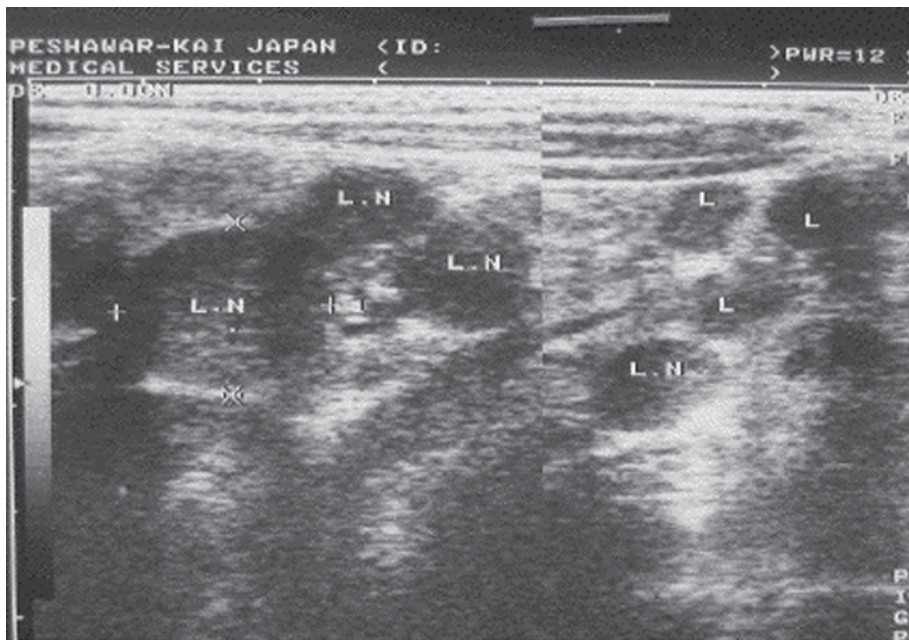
Ultrasonographic image of the culture-confirmed 8-year-old male case. Multiple enlarged lymph nodes were seen. The largest was 1.8 cm in diameter.
